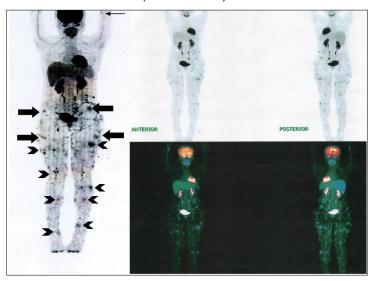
FDG-PET images show hypermetabolic diffuse subcutaneous thickening, haziness and stranding densities in the left upper arm (thin arrow), right epigastric, bilateral posterolateral lumbar regions, both pelvic, gluteal (thick arrows) and both lower extremities in keeping with known malignancy; hypermetabolic bilateral inguinal, popliteal and left paraspinal intramuscular lymph nodes are consistent with active lymphomatous disease (arrow heads); hypermetabolic foci in the tibia are suspicious for metastasis.
